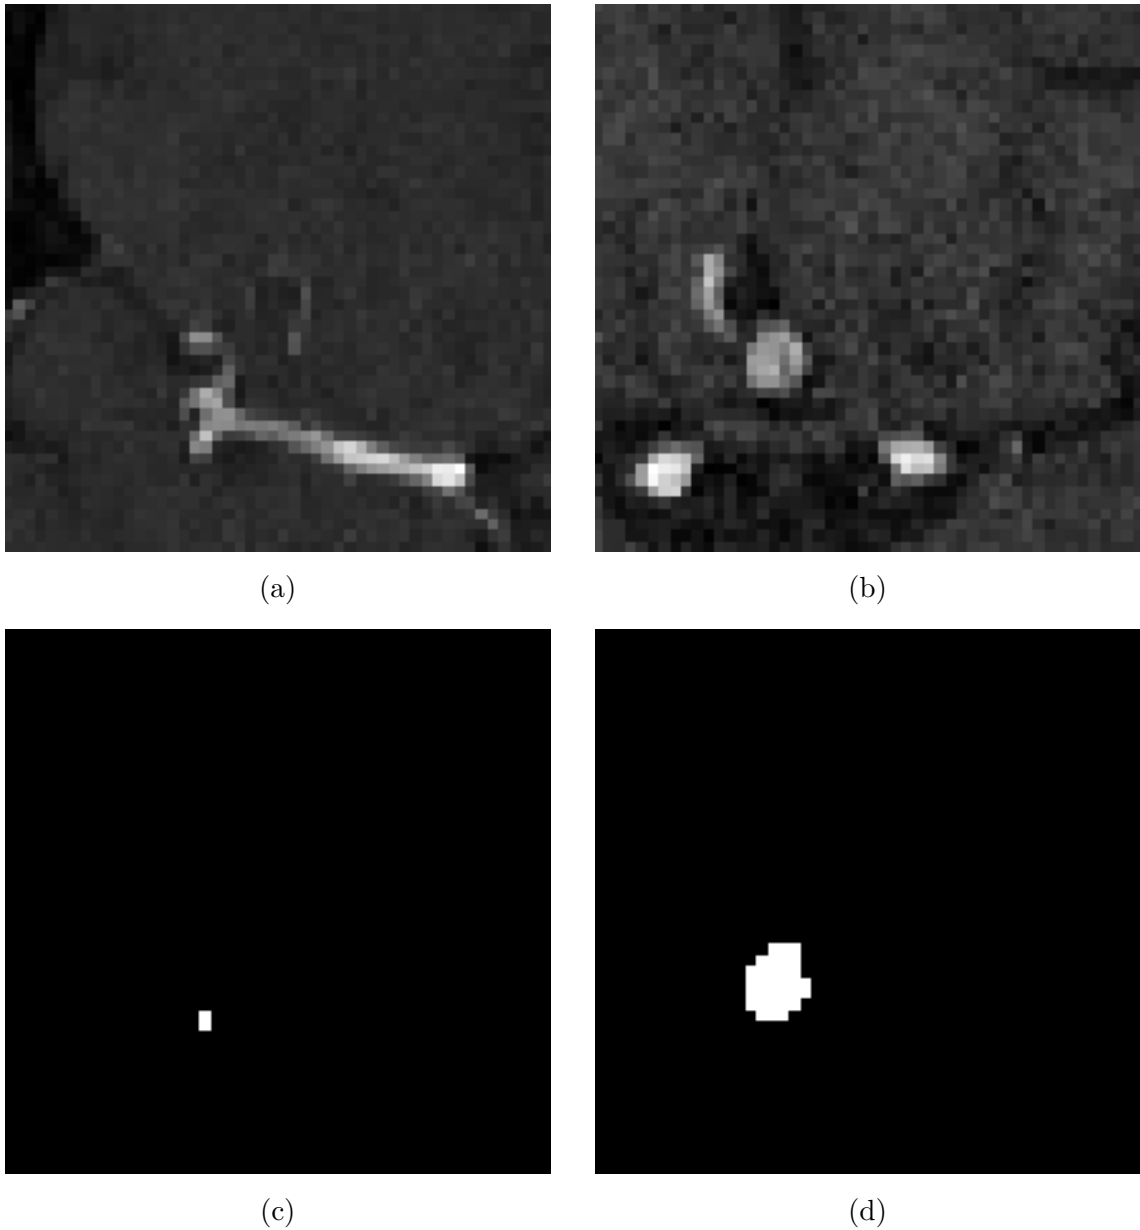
This figure shows random patches used for learning the U-net. Images (a) and (b) show patches of the TOF-MRI images. Pictures (c) and (d) are their patched references.
